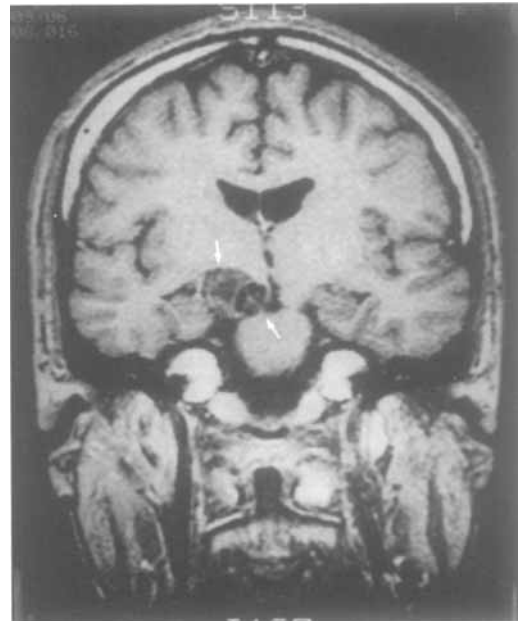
Coronal T1-weighted magnetic resonance imaging. The patent lumen is evident as a signal void in the medial part of the aneurysm, which compresses the right cerebral peduncle (arrows). The thrombosed part of the aneurysm is apparent laterally, deviating and compressing the right hippocampal formation (arrows).
